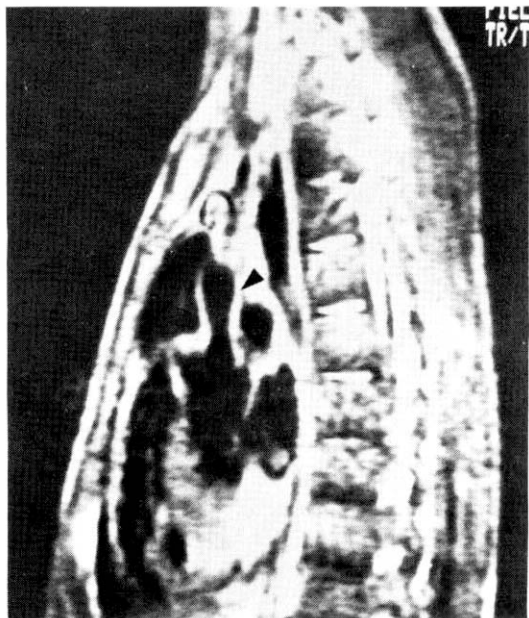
Left lateral magnetic resonance image demonstrating a supravalvular aortic stenosis (arrowhead).
